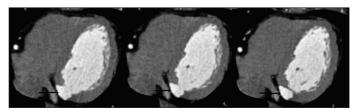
Axial CT images of the left ventricle in mid-diastole show an out-pouching structure (arrows) that originates from the left ventricular outflow tract
